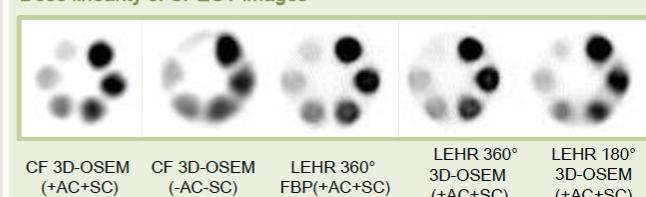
Comparison of SPECT images acquired under various conditions
